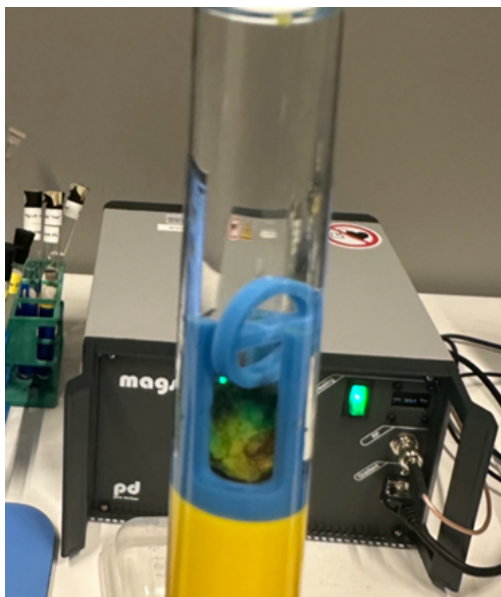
Tabletop MRI with modified bore size
